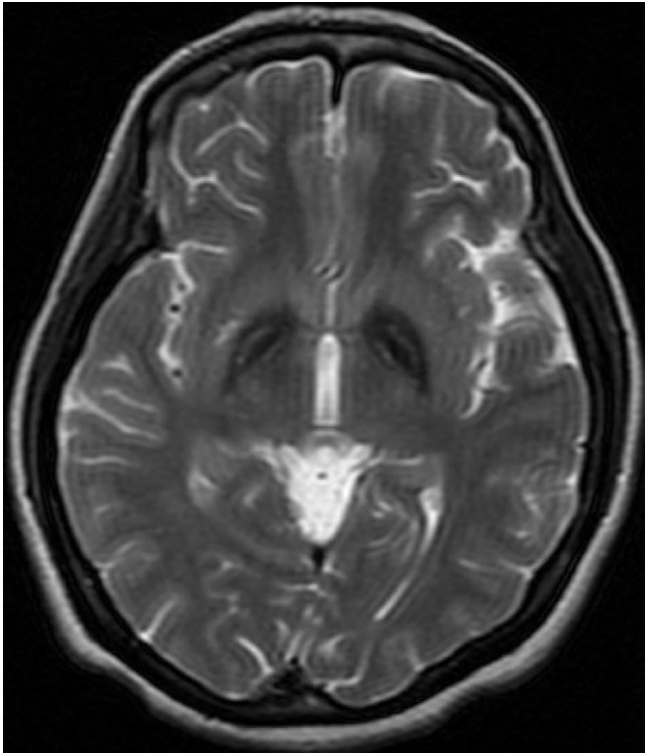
T2-weighted magnetic resonance image of the patient showing hypointensity with central hyperintensity lesions in the medial globus pallidi.
